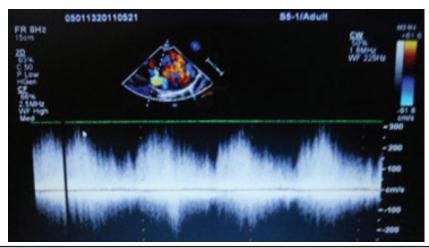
Doppler Spectral Tracing of Continuous Flow through the Fistula
